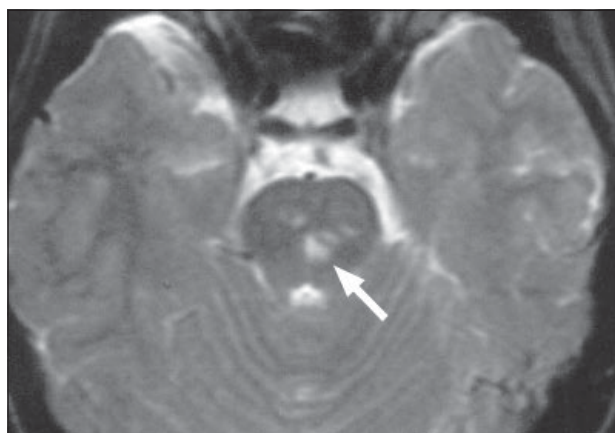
T2-weighted axial image shows small brainstem infarcts (arrow).
